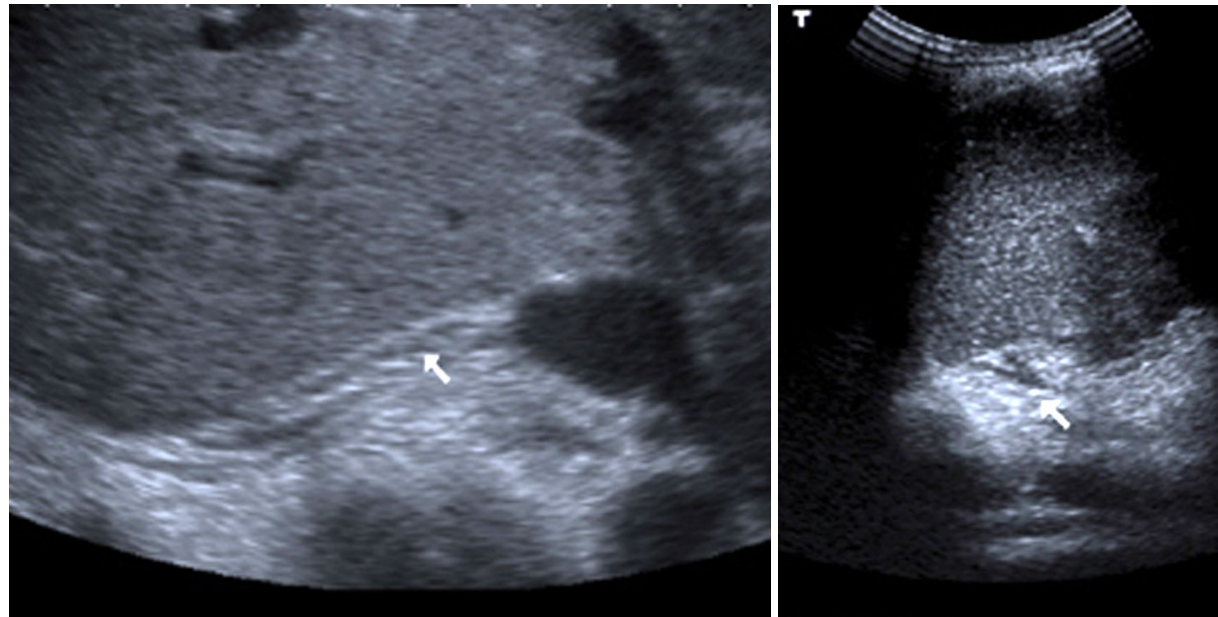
Adult abdominal ultrasound. White arrows showing two small adrenal glands. As mentioned above, it's not uncommon not to see them on US. In adults, CT or MRI are better suited for adrenal gland imaging.
